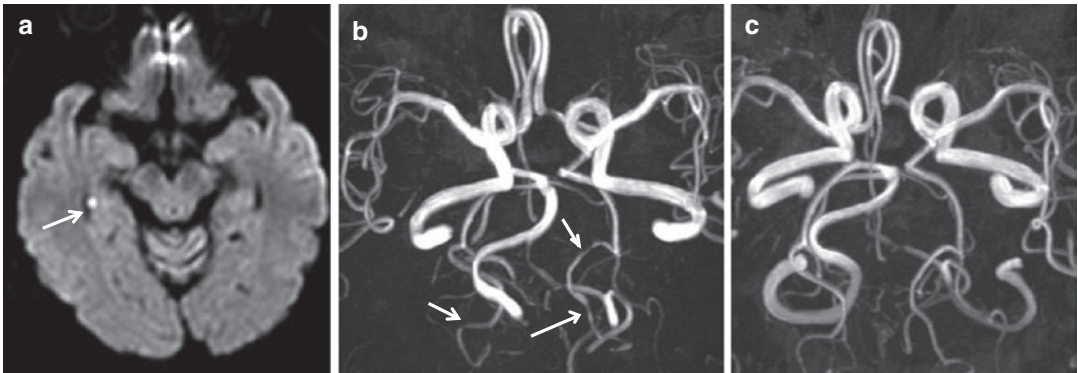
A 65-year-old woman developed sudden severe, generalized headache. Diffusion-weighted MRI showed a small, asymptomatic infarct in the right hippocampal area (a, arrow). MRA showed multiple stenosis
